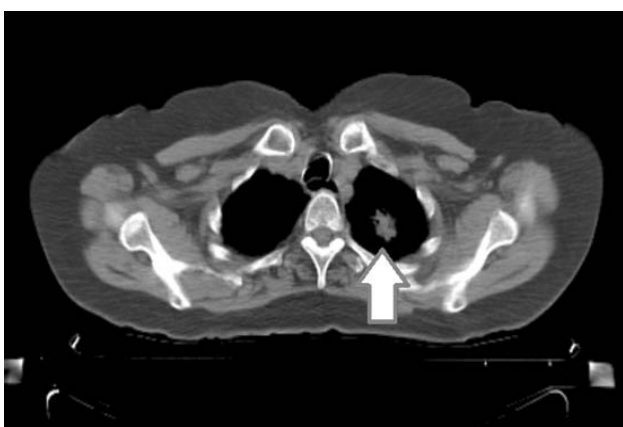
Axial CT from the chest shows pulmonary nodule in the left upper lobe
